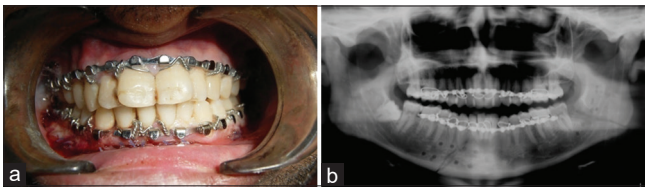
(a and b) Immediate postoperative occlusion and radiograph
